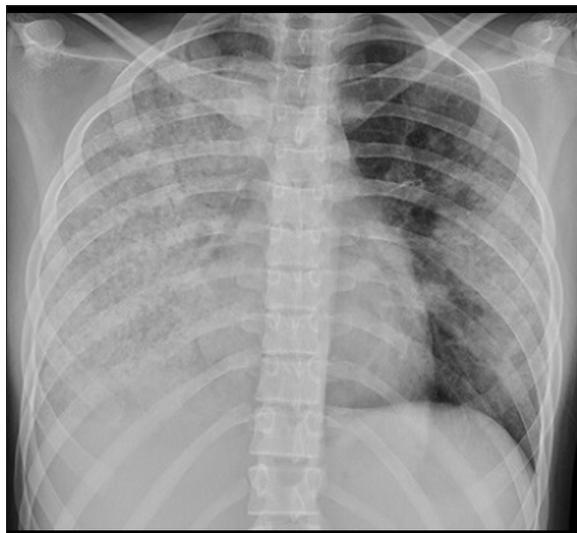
Chest X-ray: bilateral diffuse opacities
